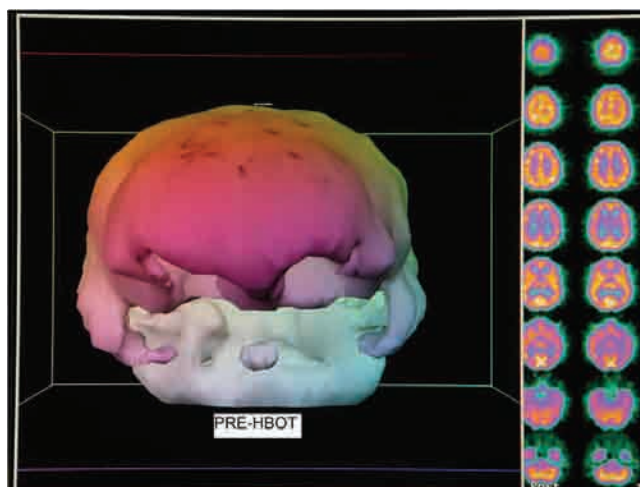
Pre-HBOT SPECT brain scan three dimensional surface reconstruction and processed transverse images. Note bilateral orbital frontal and temporal lobe defects and diffuse heterogeneous pattern of blood flow.
